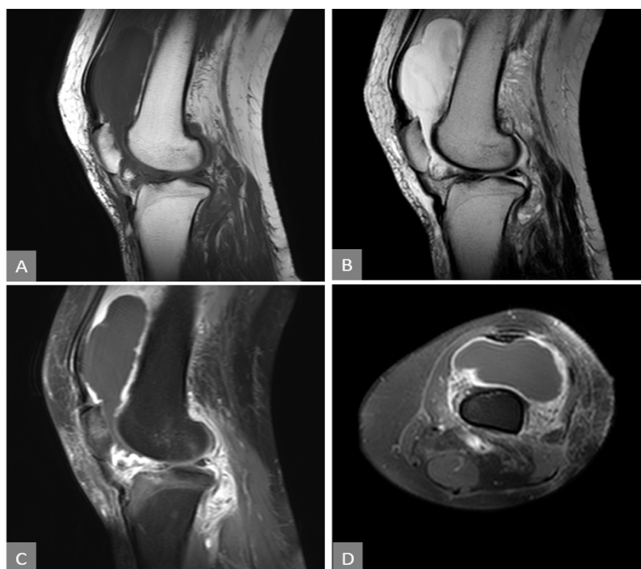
MRI of left knee shows moderate to severe knee effusion which demonstrate homogenous hypointense signal intensity on sagittal T1W (A) and heterogeneously hyperintense on sagittal T2W (B). Diffuse irregular thickening of the synovium also noted which enhances post contrast (C) and (D).
